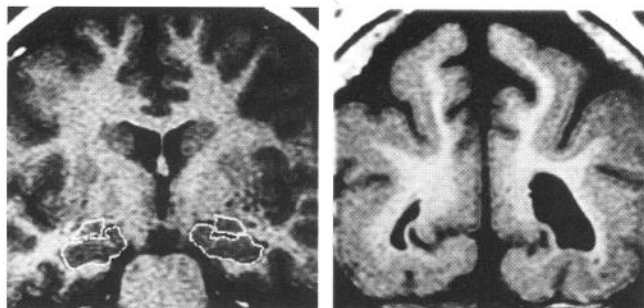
Coronal MRI scans showing normal and symmetric hippocampal and amygdaloid volumes (outlined bilaterally) on the left and bilateral parieto-occipital pachygyria on the right in a patient with secondary generalized epilepsy.
